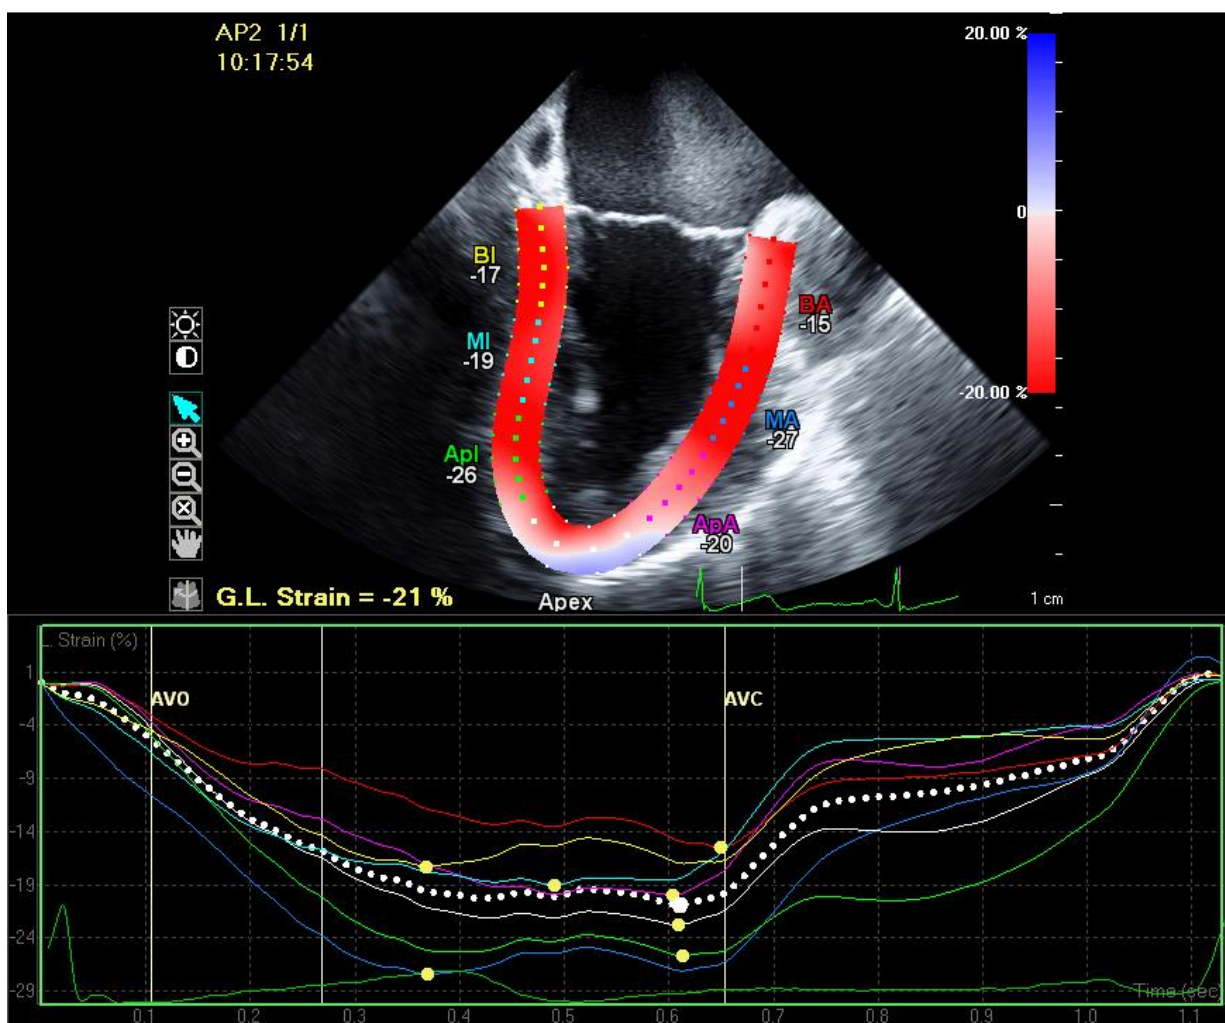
Mid-esophageal two - chamber echocardiographic view of pt no 9 depicting the left ventricle (LV), where the myocardial walls are divided into six segments distinguished by color-coded labels. Segmental strain measurements are shown adjacent to each segment. BA – basal anterior, MA – mid anterior, ApA – apical anterior, BI – basal inferio, MI – mid inferio, ApI – apical inferior.
